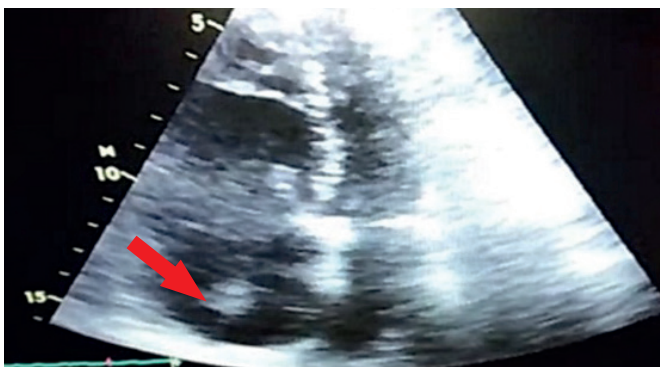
Transthoracic echocardiography (apical 4 chamber view) showing right cavities dilatation and the presence of an echogenic mass in the right atrium (red arrow).
